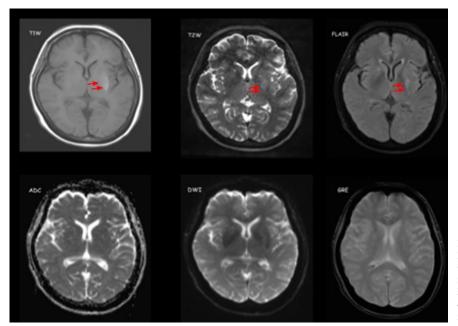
MRI: T1W, T2W and FLAIR showed heterogeneous hyperintense signal (red arrows) in the putamen and globus pallidus of the left lentiform nucleus. No area of restricted diffusion in the diffusion imaging study nor susceptible artefact on GRE were
